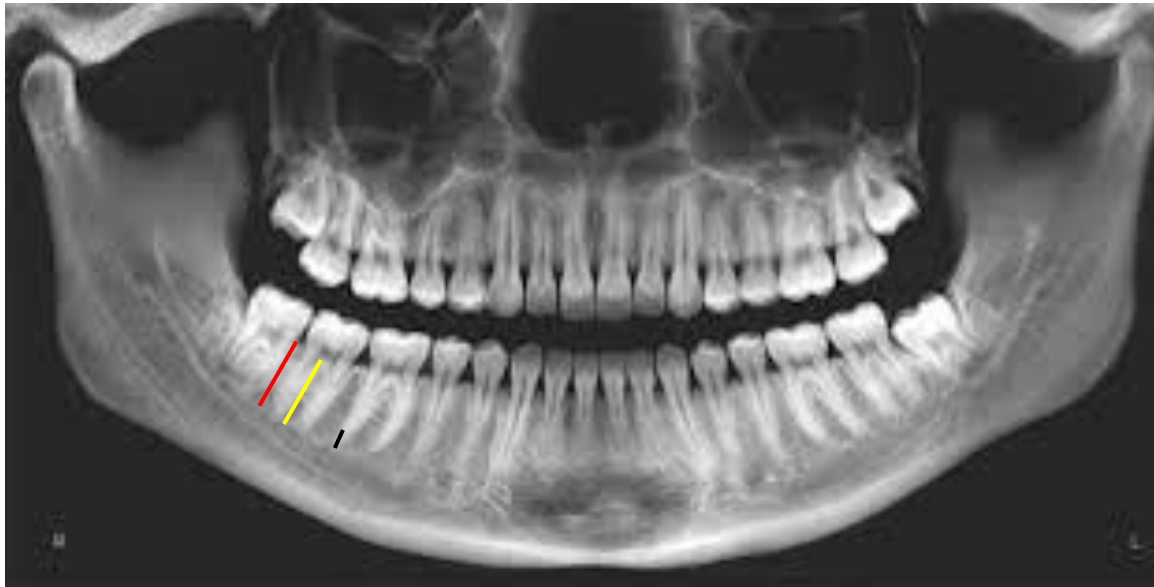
Orthopantomograph (D1- Black, D2 –Yellow, D3 - Red )
